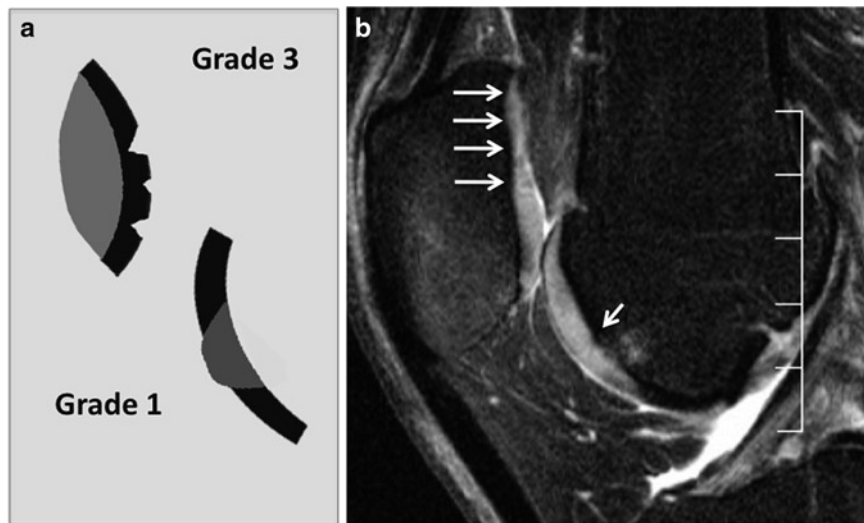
Whole-Organ-MRI-Score (WORMS) grade 3 and 1 lesion.* Graph of grade 3 and 1 knee cartilage lesions (a) and sagittal fat saturated intermediate weighted fast spin echo sequence of the knee (b) showing a cartilage WORMS grade 3 lesion at the patella and a grade 1 lesion at the trochlea. The lesion at the patella measures more than
